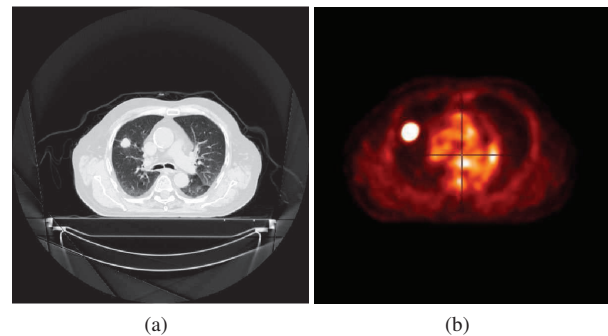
Clinical case with a lung tumor: (a) CT modality and (b) PET modality.
